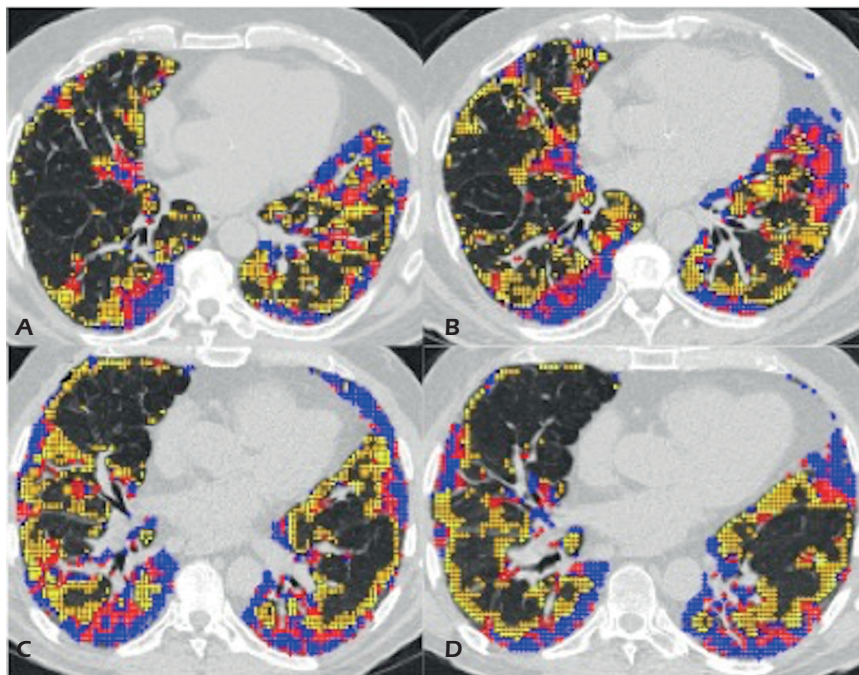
HRCT Images Segmented for QLF and QGG. *A-B*, Subject 1 from Cohort 1: (*A*) QLF (blue + red dots) 14.8% and QGG (yellow dots) 13.8% at baseline; (*B*) QLF 21.4% and QGG 15.2% at Week 48. *C-D*, Subject 6 from Cohort 2: (*C*) QLF 27.3% and QGG 20.0% at baseline; (*D*) QLF 25.8% and QGG 19.4% at Week 48.
